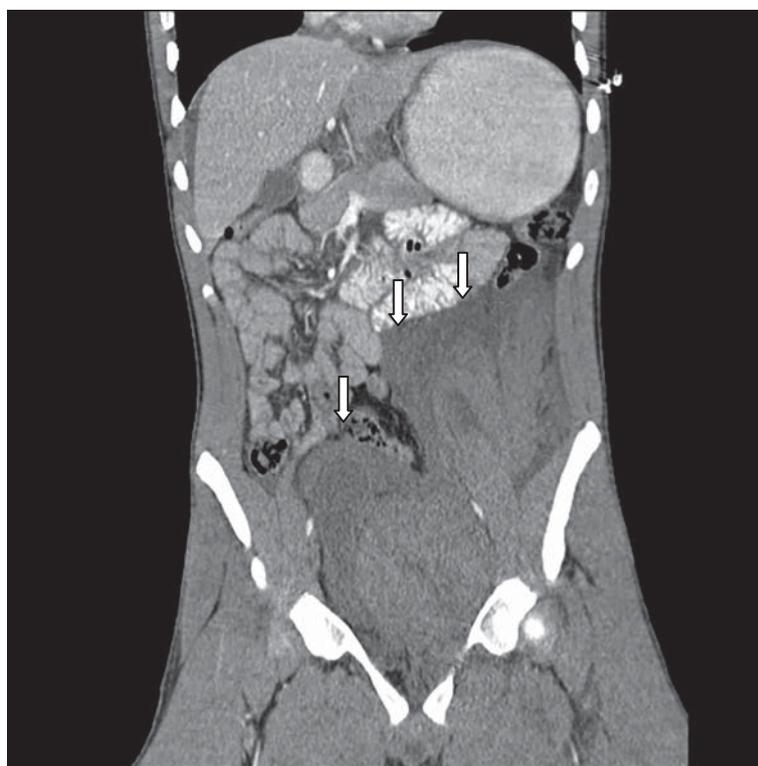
Enhanced CT shows extraperitoneal haematoma (below arrows).
